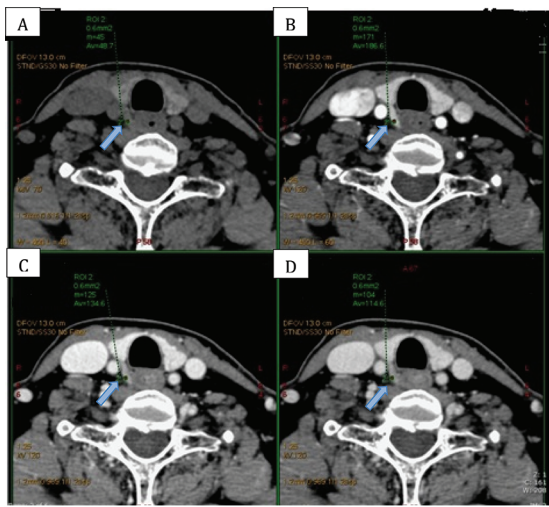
A 60-year-old female with PHPT. Prior MIBI scan was negative. 4D-CT showed early enhancement with contrast washout lesion at right lower aspect of thyroid gland, which is suggestive of HPG. This lesion was pathologically proven parathyroid adenoma.
